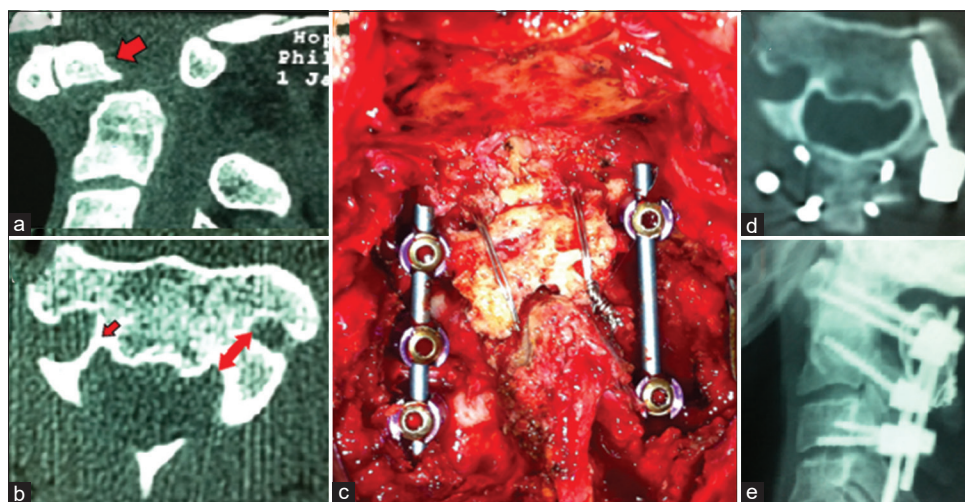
Imaging from case 9, the male of 40 years old. (a) Sagittal computed tomography, the arrow shows the Os odontoideum. (b) Axial computed tomography passing through C2; the arrows show the difference in thickness between the left pedicle where screwing is safe and the right pedicle where screwing is dangerous due to pedicle congenital hypoplasia. (c) Per-operative photography showing left C1 lateral mass, C2 pedicle, and C3 lateral mass screws; on the right side C2 pedicle screwing was skipped; this image shows also the bone graft placement between the posterior arch of C1 and spinous process of C2; hold in place by classic wiring technique. (d) Axial computed tomography passing through C2 showing pedicle screw placement on only the left side. (e) Postoperative lateral X-rays showing the construct placement
